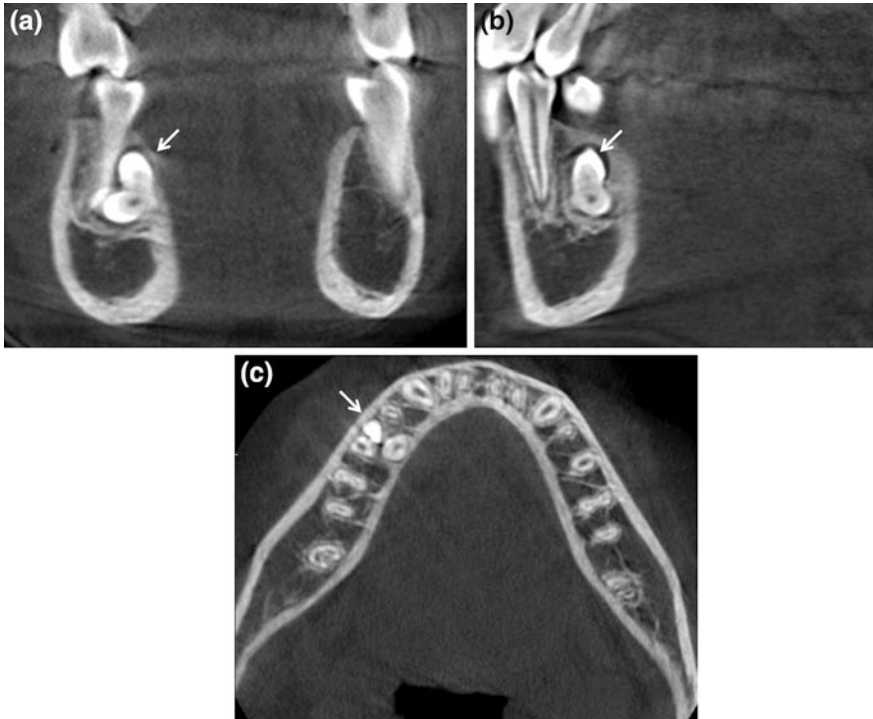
CBCT coronal (a), sagittal (b) and axial (c) sections demonstrating, in correspondence of the lingual plate of the root of 45, a radiopaque masse that has tooth like appearance and density (*thin arrow*). The radiographic signs suggest a benign process and are consistent with compound odontoma
